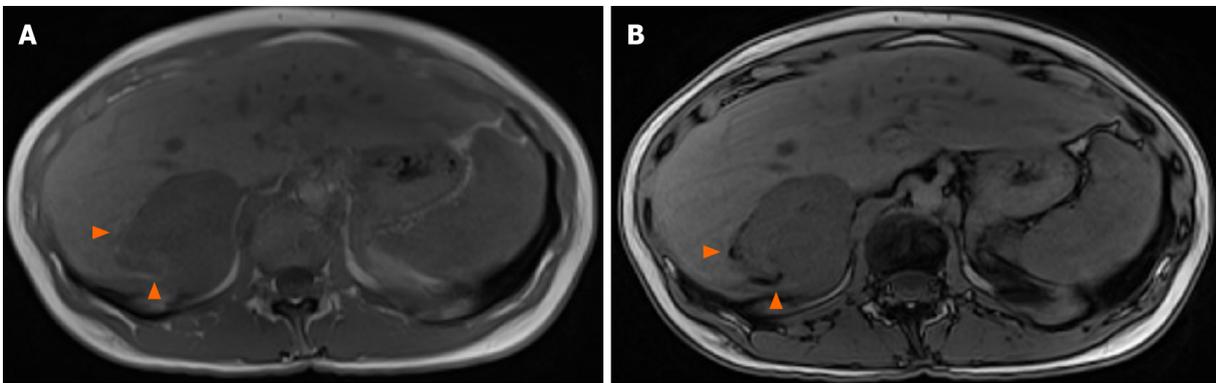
T1 weighted magnetic resonance images. Signal dropout at the periphery of the lesion due to fat contingents (arrowhead). A: In-phase; B: Opposed-phase.
